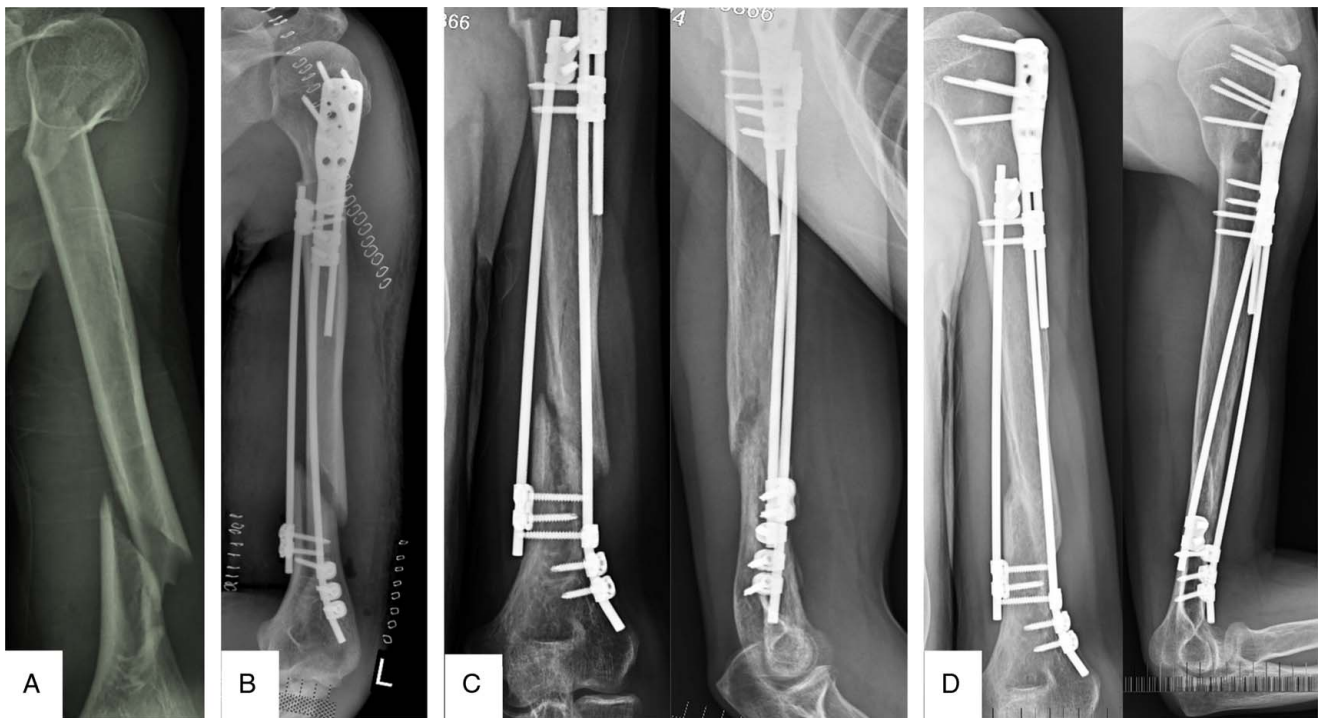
Multifragmentary HSFs are easy for medial minimally invasive technique. (A) X-Ray of preoperation. (B) X-Ray on the day after surgery. (C) X-Ray at 18 weeks. The fracture consolidated. (D) X-Ray at 18 months.
